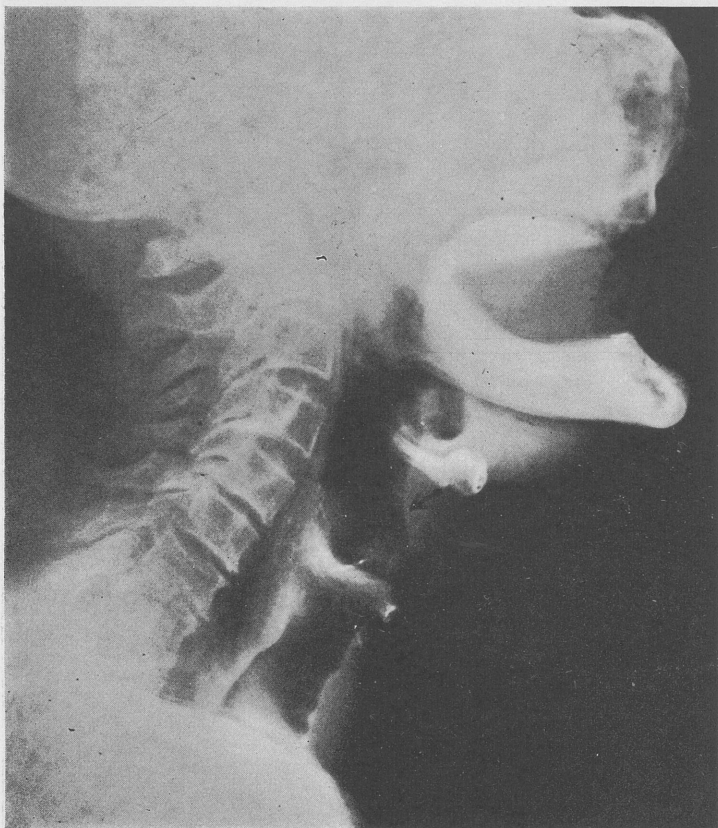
Lateral roentgenogram of the neck showing location of the lesion on the under surface of the epiglottis. (Roentgenogram by Dr. Pancoast.)
